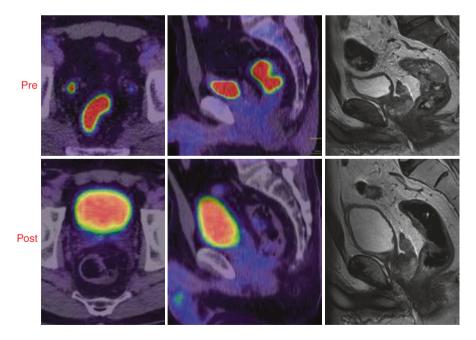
Complete pathological response of rectal cancer on imaging (PET and MRI) pre and post neoadjuvant chemoradiotherapy
